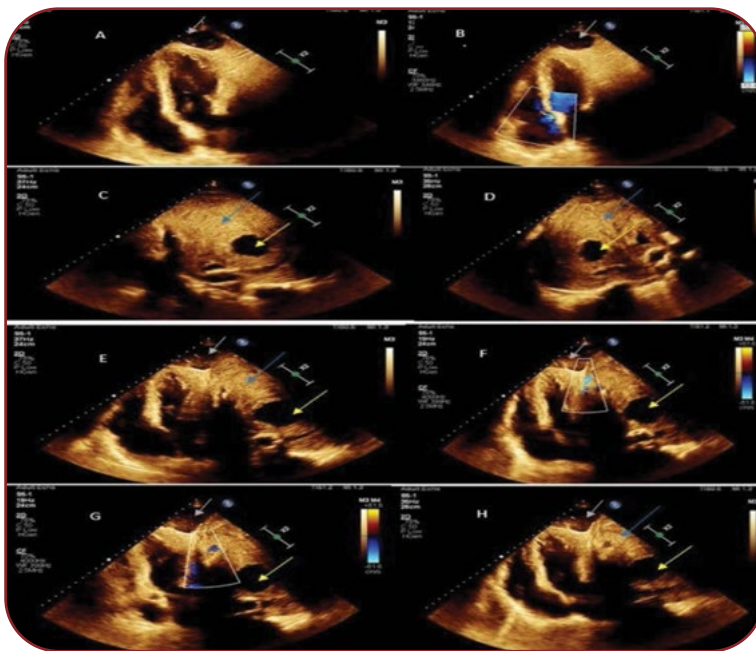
Transthoracic echocardiography – apical section four chambers (A, E, F, H); two chamber view (G); colour Doppler examination (B, F, G); A, B, E, F, G, H (grey arrow) collapsed left lung parenchyma; C, D, E, H (blue arrow) massive periaortic hematoma; and C, D, E, F, G, H (yellow arrow) true aortic lumen.
